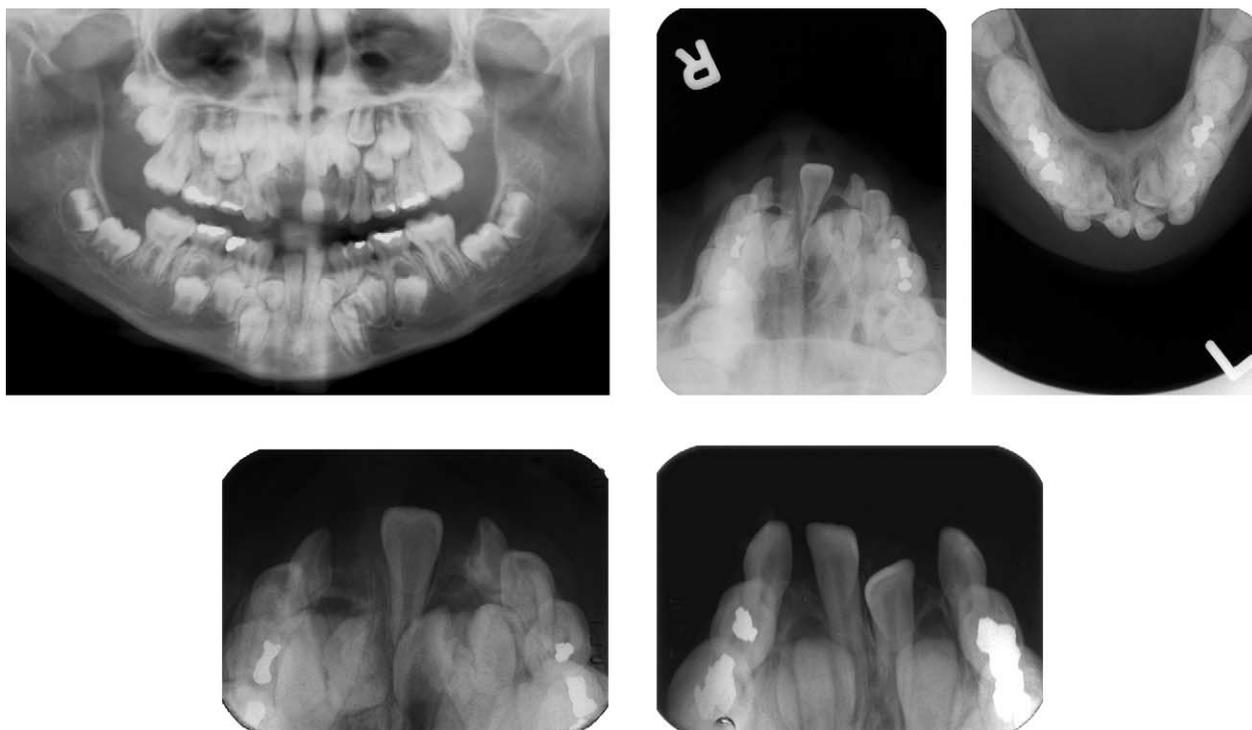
Diagnostic panoramic and occlusal radiographs.
